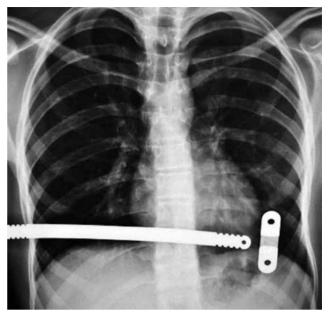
Bar dislocation is shown in chest X-ray in late period.
